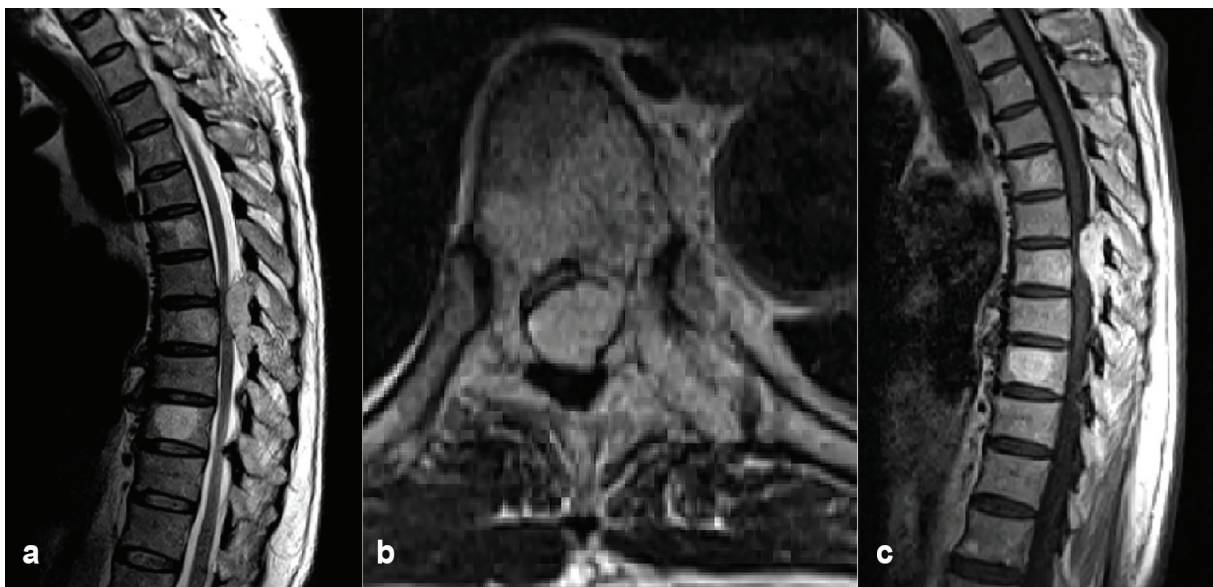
Magnetic resonance imaging features of the presented case shows an extradural extramedullary mass in the posterior epidural space compressing the spinal cord a) sagittal T2, b) axial T1, and c) axial T1 with Gad injection.
